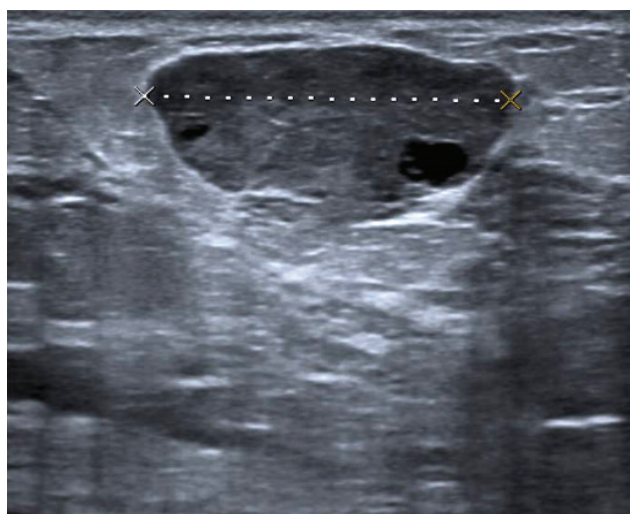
Ultrasonographic appearance of the nodule, demonstrating an oval well-circumscribed lesion with cystic areas inside
